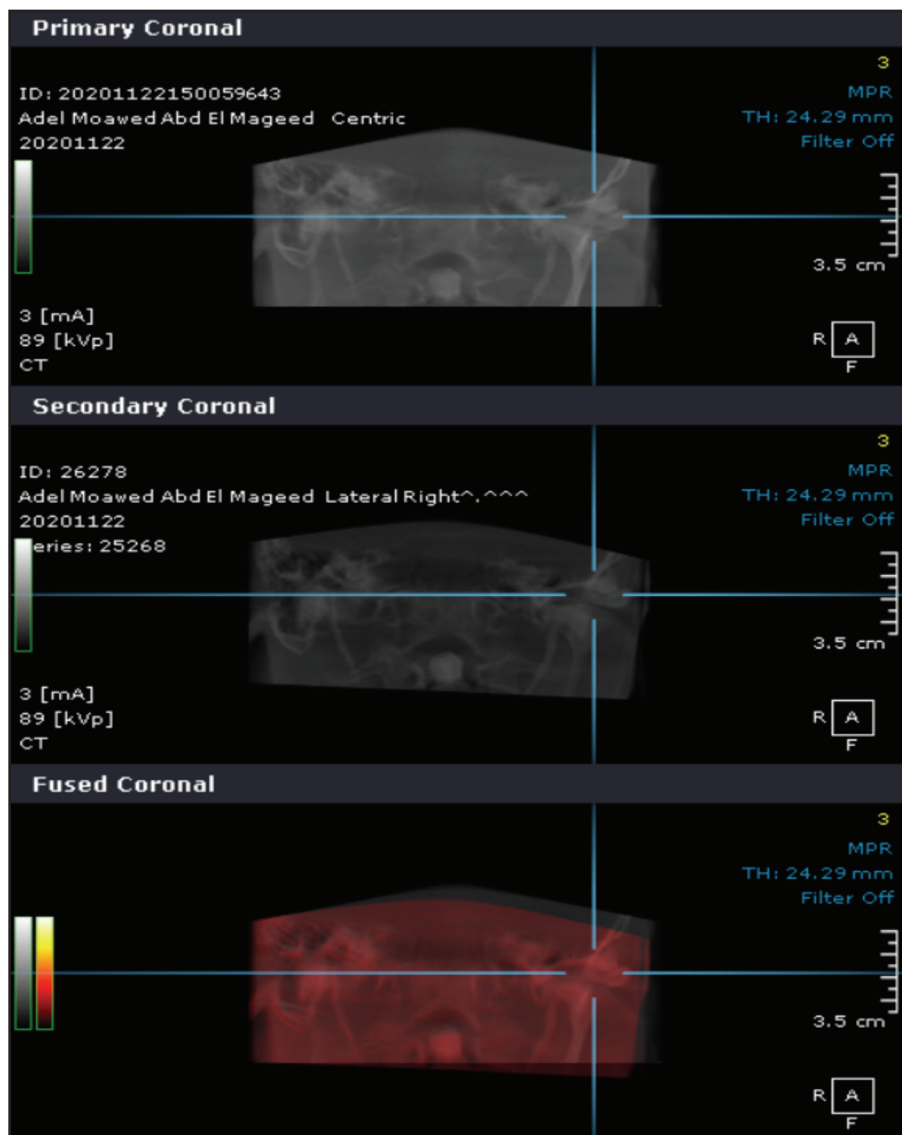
Cone beam CT showing condyle in centric and lateral movement.
